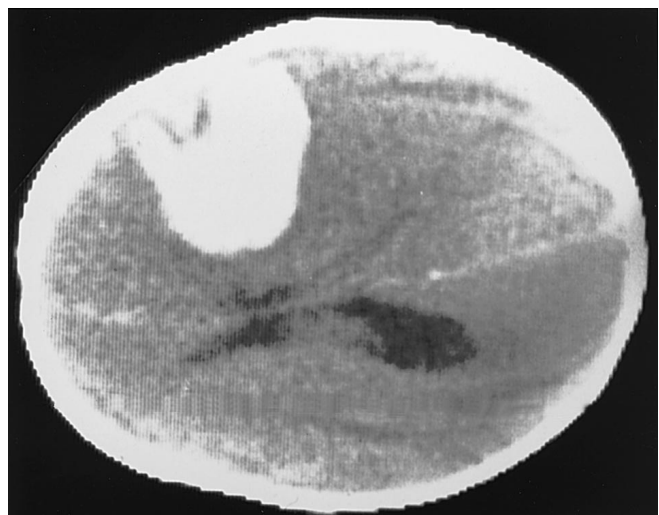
CT-scan: large right intraparenchymal hematoma and marked deviation of the interhemispheric fissure
